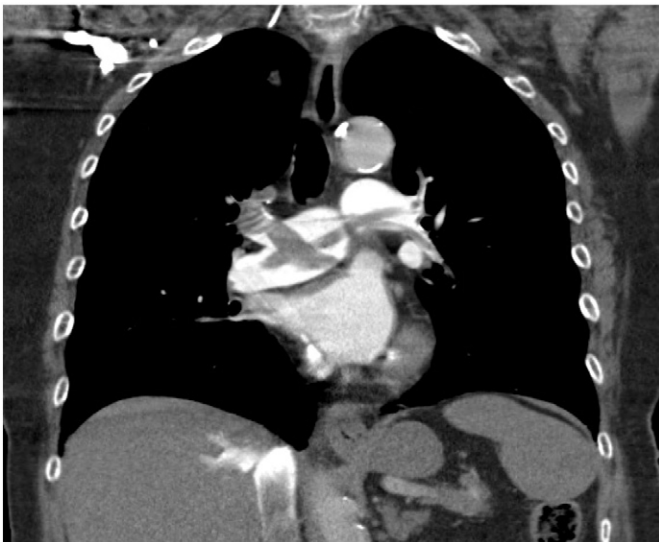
A representative example of a CT pulmonary angiogram demonstrating extensive bilateral and saddle PE in the coronal plane.
